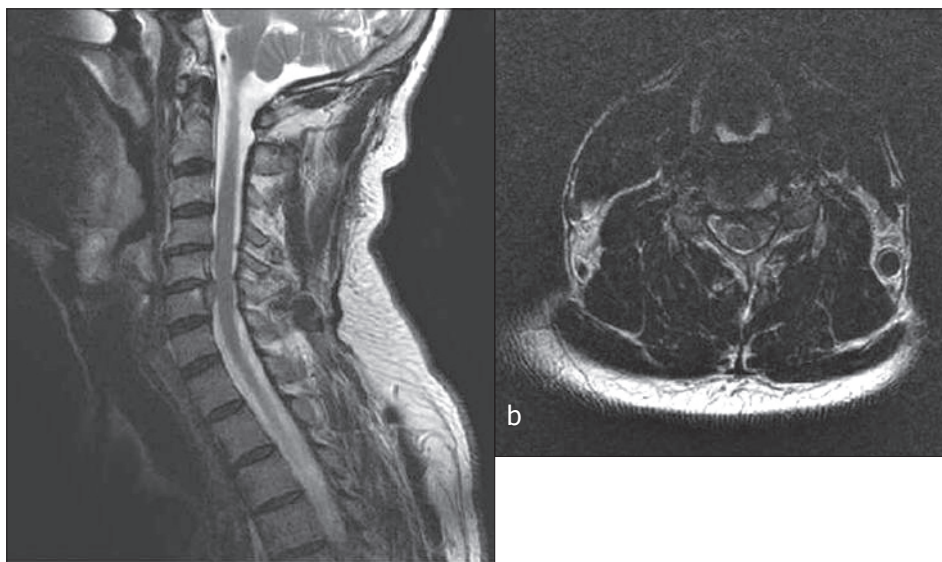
Magnetic resonance images in sagittal (a) and axial (b) T2-weighted views revealing large C5-C6 disc extrusion, through a disruption of the anulus fibrosus, eccentric to the left side and compressing the anterior aspect of the spinal cord.
